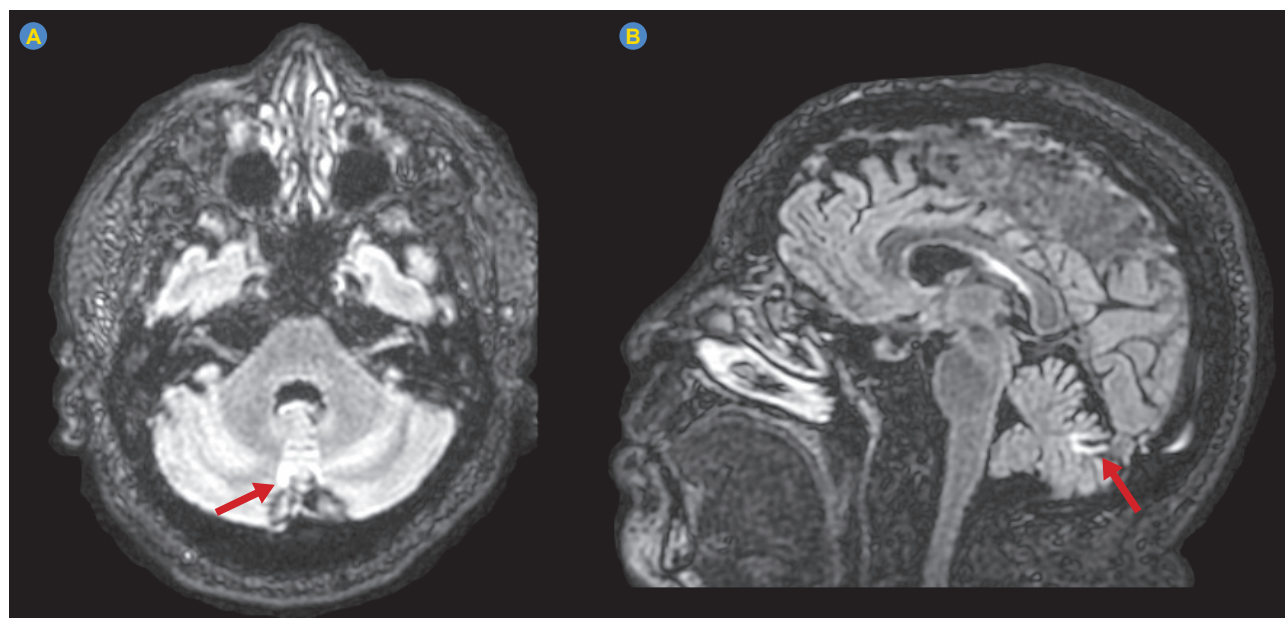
T2/FLAIR sequence showing an hyperintensity in the paravermian region bilaterally, suggestive of an ischemic lesion
